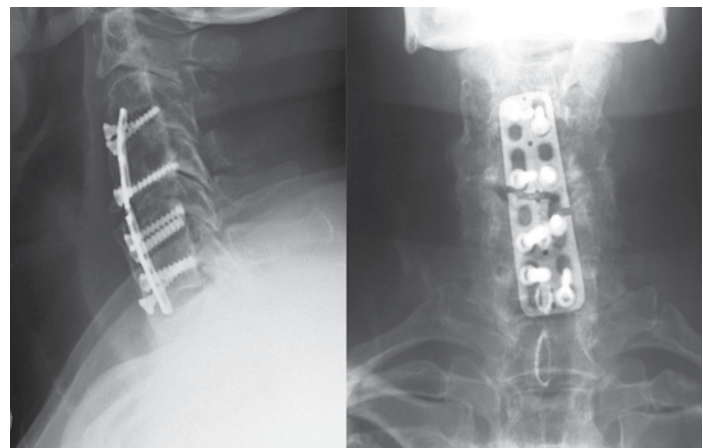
Case example of a patient with implant failure and pseudarthrosis. This 49-year-old man presented with neck pain and radiculopathy and underwent a 3-level anterior cervical discectomy from C4 to C7 using a Caspar plate and allograft. At last follow-up 10 years later, he had a fractured screw, multiple screws that had backed out, a pseudarthrosis, and plate fracture at the C5-6 level as seen on the anteroposterior (left) and lateral (right) plain radiographs. The patient was nevertheless doing well, with resolution of his radicular symptoms, and there was no need for further surgery.
